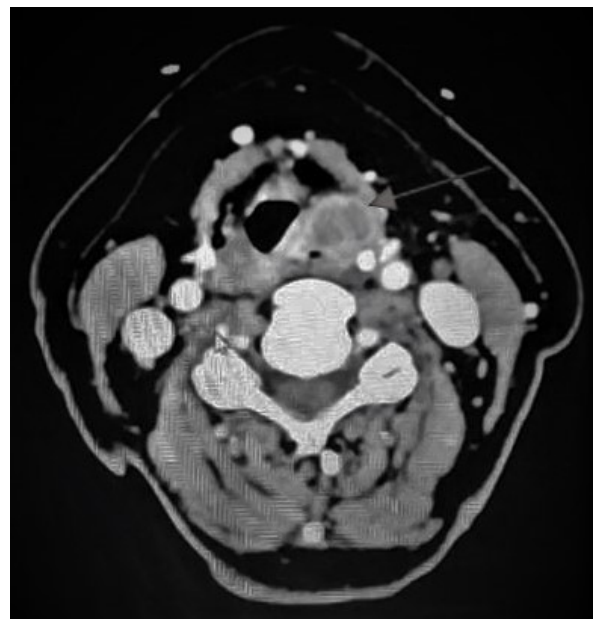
Axial view of CT neck shows a hypodense lesion at left hypopharynx (red arrow) that causes mass effect causing slight narrowing of the hypopharynx.
